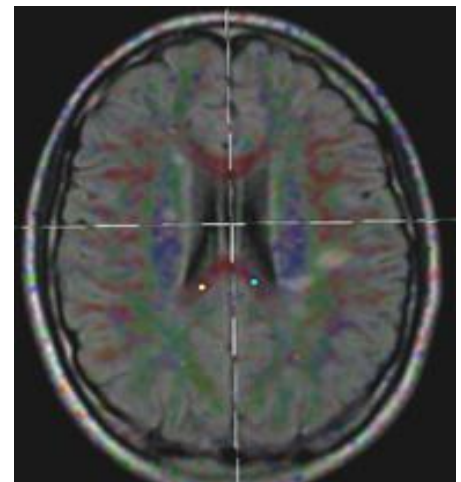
Case (3) fused FLAIR/DTI Axial image
